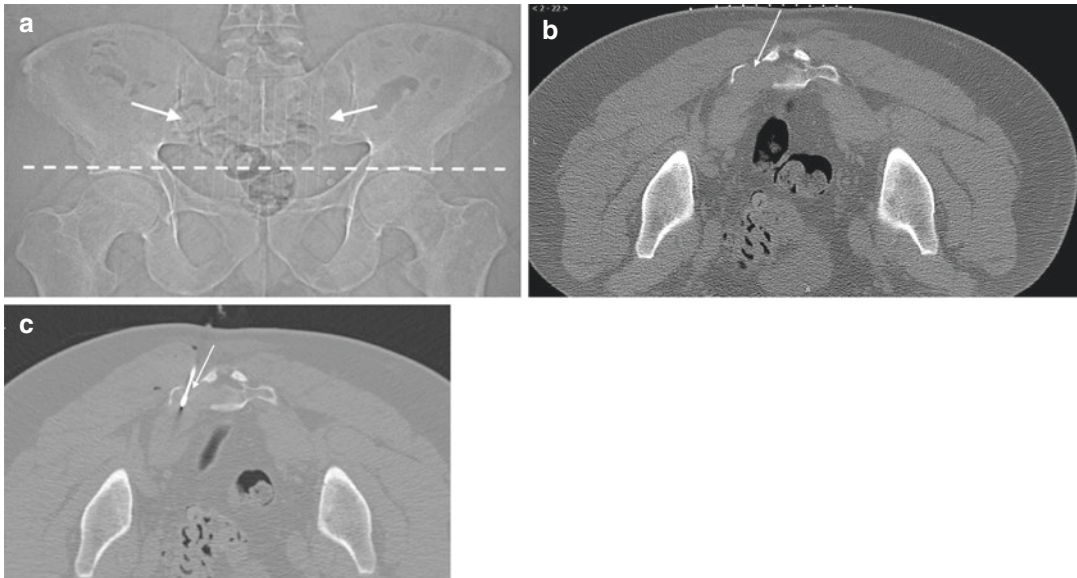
A 47-year-old male with sacral lesion detected on an MRI examination. Scout frontal image (a) from CT biopsy procedure shows skin grid markers (arrows) oriented vertically over the sacrum. The dashed line indicates the level of the lower sacrum. Axial CT image (b) shows lytic soft tissue mass (arrow) within the left lateral
